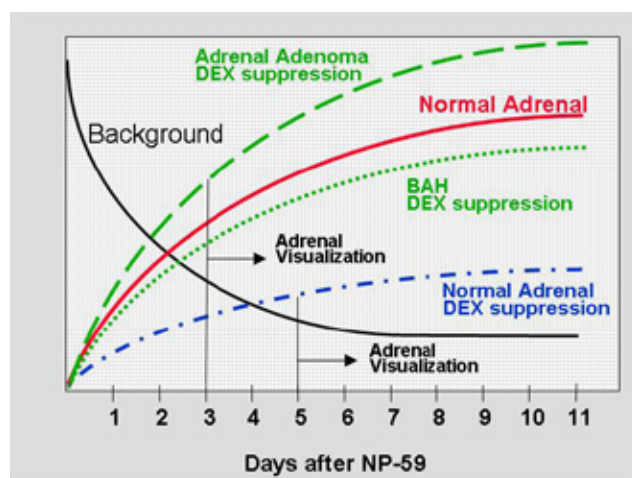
The pathophysiological basis of adrenal scintigraphy in PA. Normal adrenals are usually visualized a few days after NP-59 administration, at a time that the gradually increasing adrenal tracer uptake surpasses decreasing background activity. When uptake is partially suppressed by dexamethasone (DEX), normal glands are visualized usually on day 5 or later. Hyper-functioning adrenals are visualized earlier than day 5, even under dexamethason suppression.
